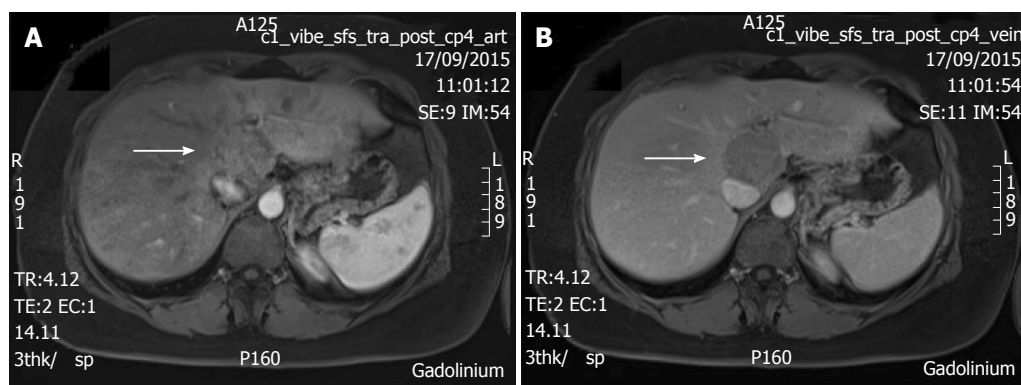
T1 weighted magnetic resonance imaging with gadolinium injection, showing a 50-mm tumor in segment 1 (arrow). A: Arterial phase; B: Portal venous phase.
